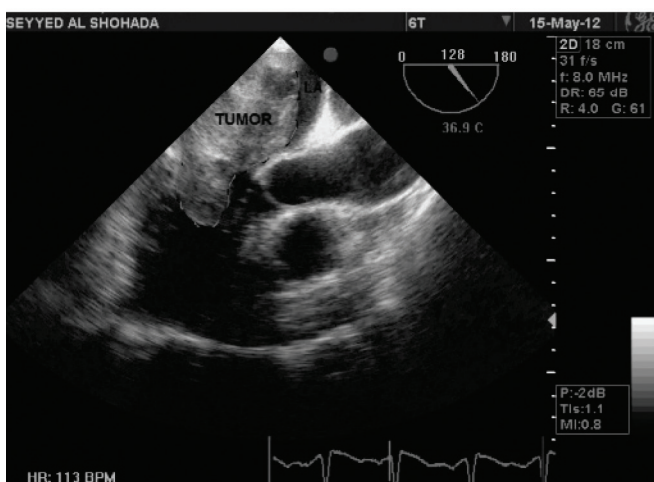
echocardiographic view of large left atrium tumor
